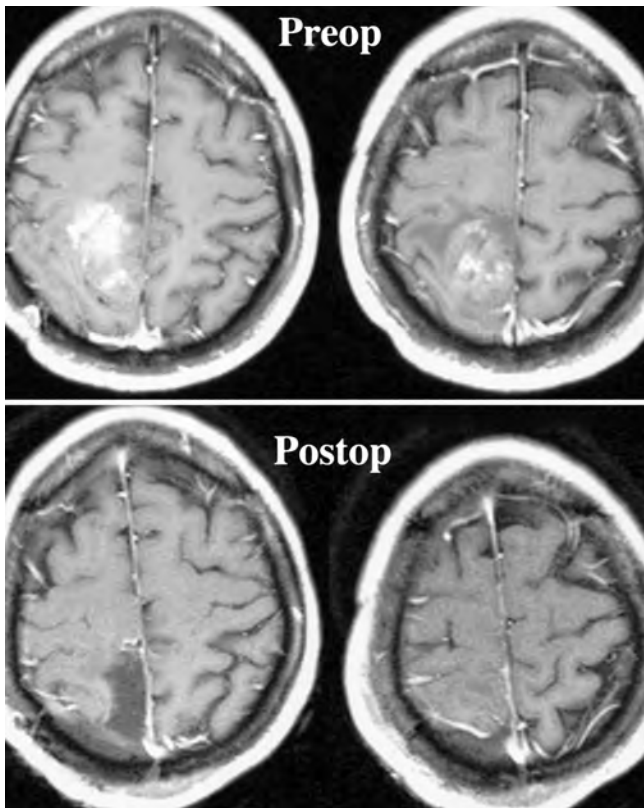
Case 1. *Upper*: Preoperative MR images revealing a predominantly enhancing glioma involving the right superior parietal lobule and postcentral gyrus. *Lower*: Postoperative MR images obtained after gross-total tumor removal
